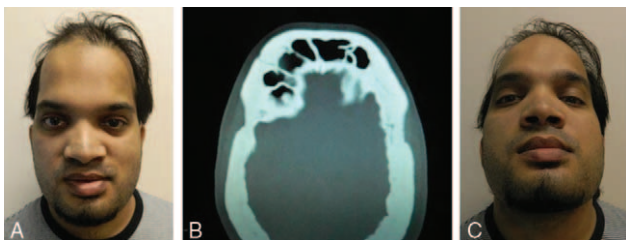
Preoperative frontal photograph of young patient with large, bilateral, frontal bone neoplasm (A), axial computed tomography scan image of skull neoplasm (B), and worm's eye photograph demonstrating preoperative bilateral temporal hollowing deformity (C).
